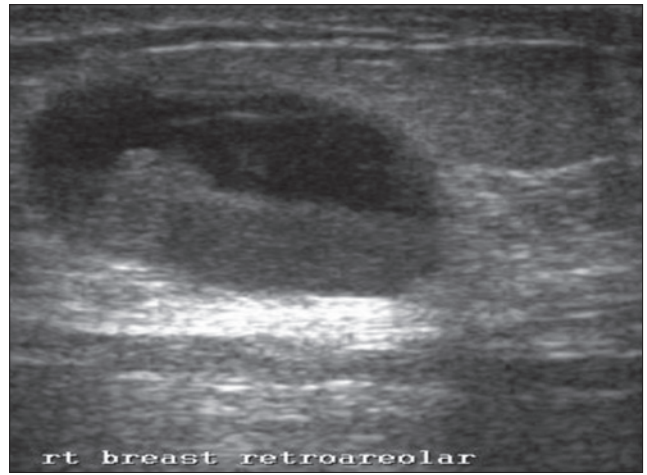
Breast sonogram obtained in 45-year-old female shows mobile debris with a fluid-debris level in a symptomatic cyst in right breast retroareolar region
